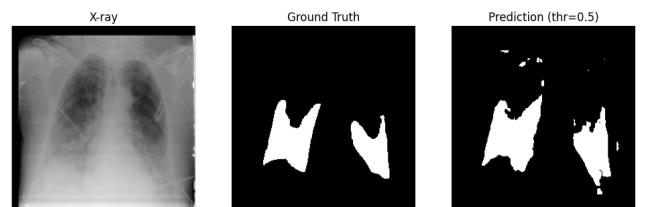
Qualitative comparison: input X-ray (left), ground-truth mask (middle), and predicted mask (right) at threshold 0.5.
